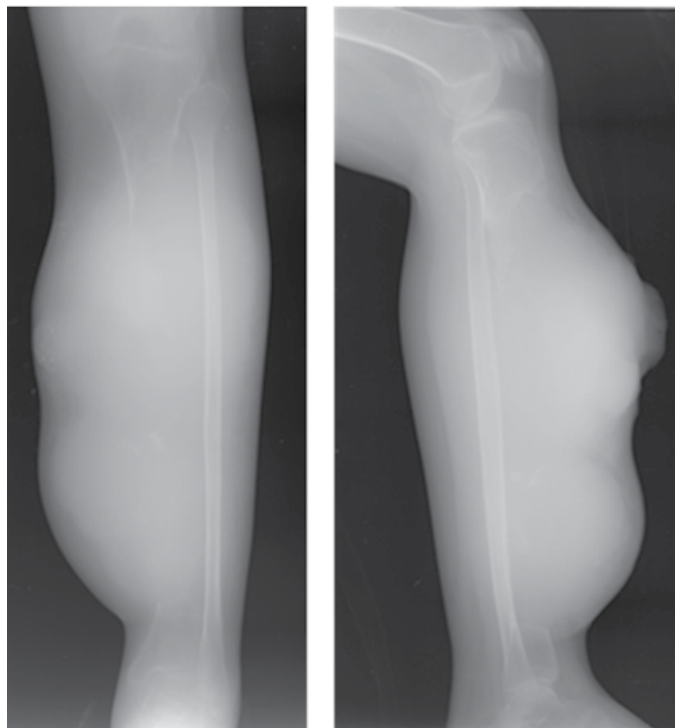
Anterior and lateral X-ray of the left leg showing a lytic lesion in diaphysis and metaphysis of the left tibia with osteodestruction of tibia and extension to the surrounding soft tissue
